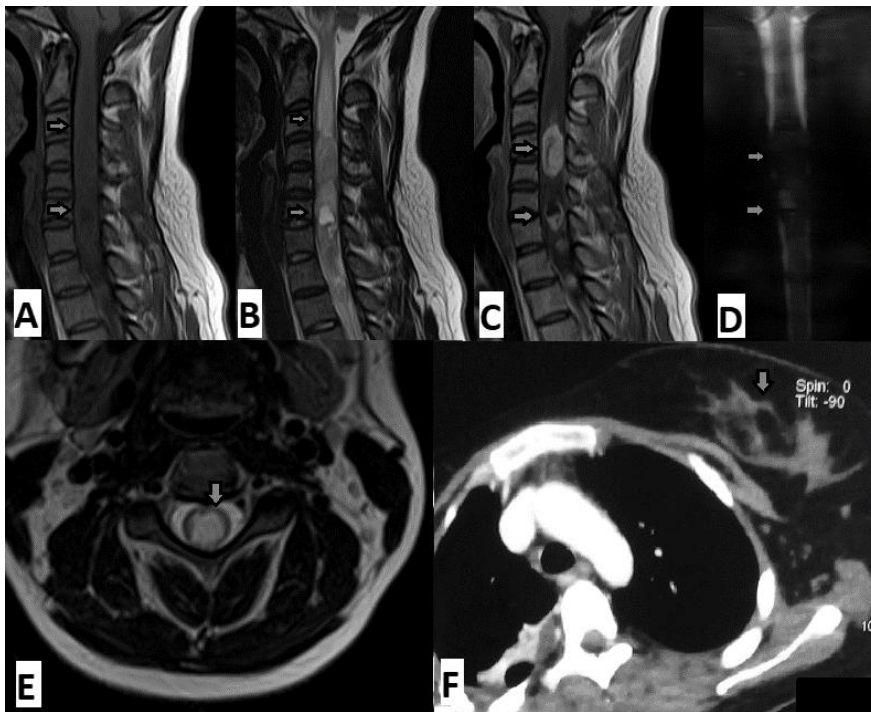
Images of patient 3. (A): sagittal T1 WI spinal MRI, the tumour appears isointense and hypointense with spinal cord swallowing (arrows); (B): sagittal T2 WI spinal MRI, the tumour appears with heterogeneous signal mostly hyperintense with the presence of myelomalacia and a cyst (arrows); (C): sagittal T1 WI injected spinal MRI, heterogeneous enhancement of multiple nodules (arrows); (D): MR-myelography, objectifies the amount of swallowing the tumour was creating; (E): axial T2 WI spinal MRI, showing spinal cord compression by an intramedullary formation (arrows); (F): thoracic CT, showing the left breast suspect nodule (arrow).
